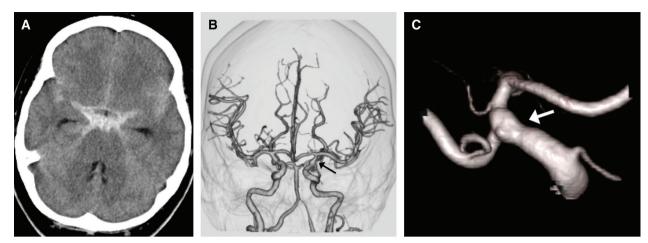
CT on admission. (A) CT shows diffuse subarachnoid hemorrhage. (B) CT angiography shows minor dilatation of the left C2 portion of the left ICA (arrow). (C) Left carotid angiography (3D
